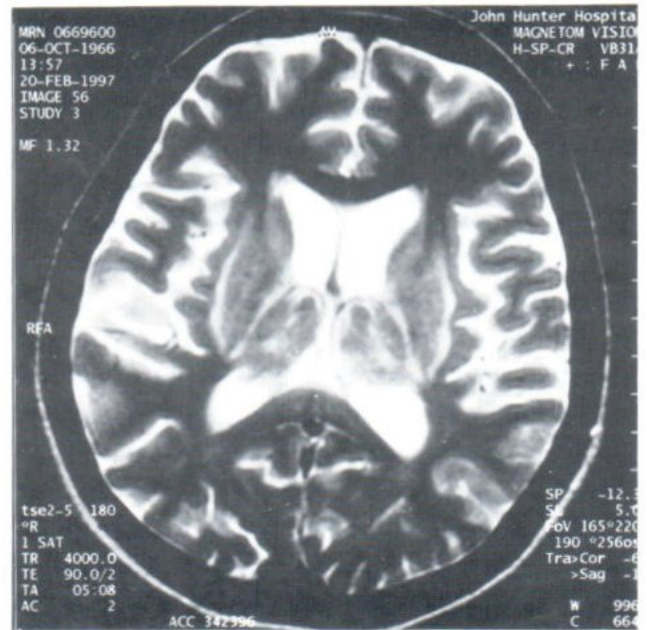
Axial T2-weighted image. High signal intensity in putamen particularly involving the outer rim, caudate nuclei and thalami. Low signal intensity areas are present within the hyperintense basal ganglia.
